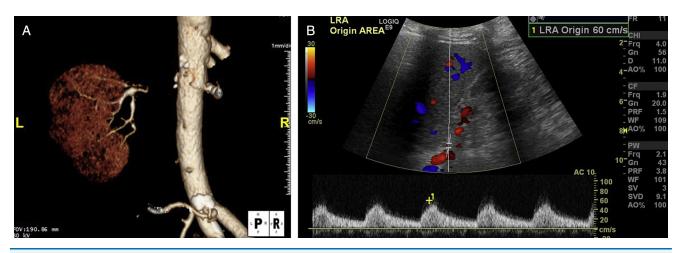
Renal imaging. (A) Posterior view computed tomography angiogram with total occlusion of flow in the proximal left renal artery (LRA) with visualization of distal vessels and kidney by angiography suggestive of evidence of preserved distal perfusion. Collaterals cannot be visualized. (B) Ultrasound of the LRA with spectral Doppler analysis shows a waveform with a delayed upstroke and a dampened tardus parvus.
